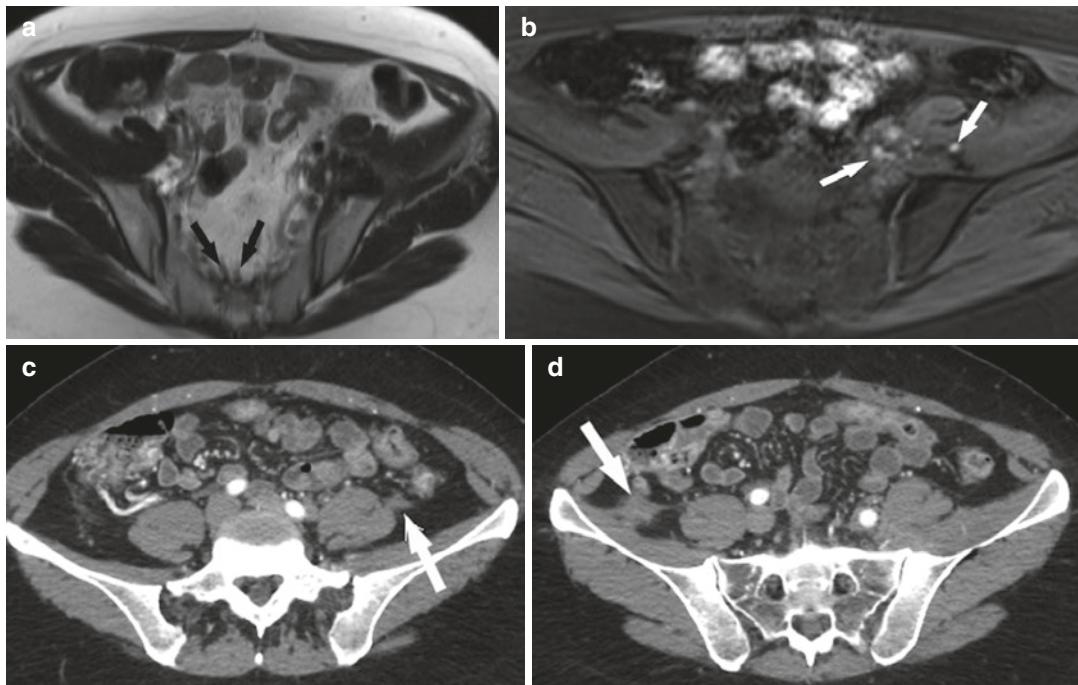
(a) T2-weighted axial MR image of the pelvis of a 28-year-old woman patient with a history of unexplained left-sided deep venous thrombosis, shows areas of low T2 signal intensity along the left sacroiliac joint not seen prospectively (dark linear areas just anterior to the sacrum outlined by two black arrows). (b) Fat-saturated T1-weighted axial MR image shows several foci of high signal intensity, separate from the colon, located next to
